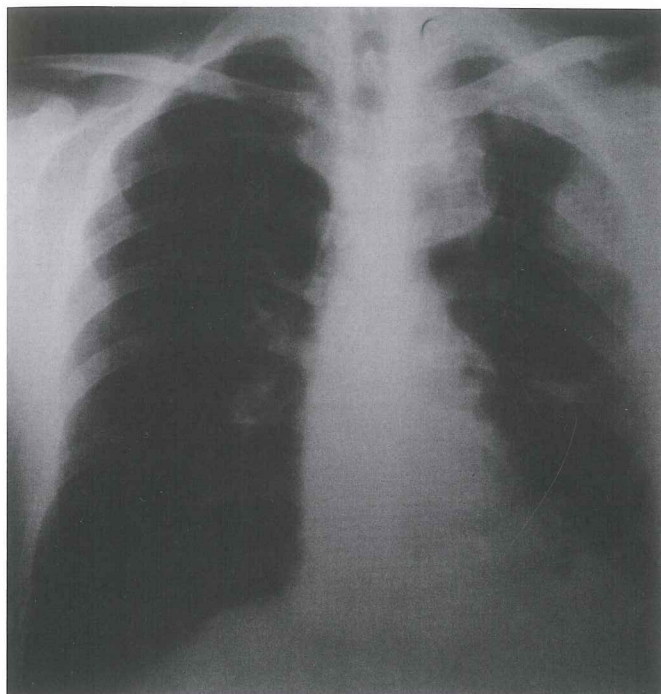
Posteroanterior chest radiograph showing multiple masses located in the left hemithorax.
